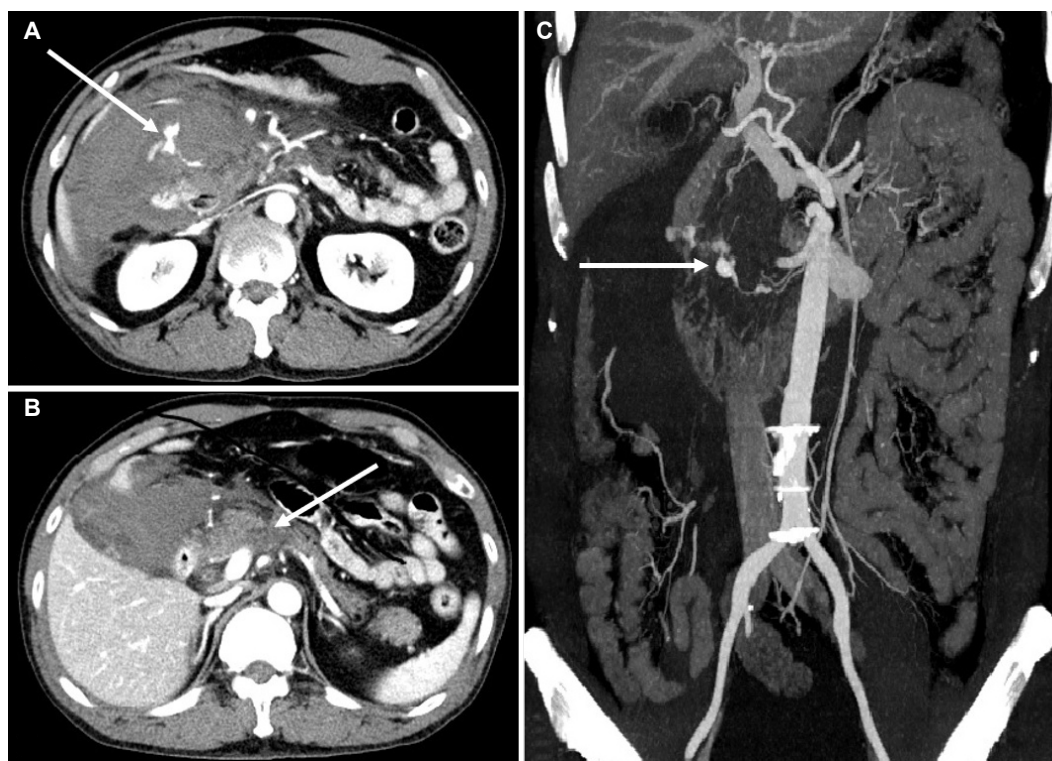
Initial computed tomography (CT) performed in the emergency department. (A) Axial CT demonstrating contrast extravasation of the inferior pancreaticoduodenal artery (PDA) (arrow), which appears to be due to an aneurysmal sac, and large acute hematoma in the right anterior pararenal space and perihepatic space are shown. (B) CT revealing a mild hypodense lesion at the pancreas head, suggesting acute pancreatitis (arrow). (C) Maximum intensity projection image revealing aneurysmal dilatation of the inferior PDA (arrow).
